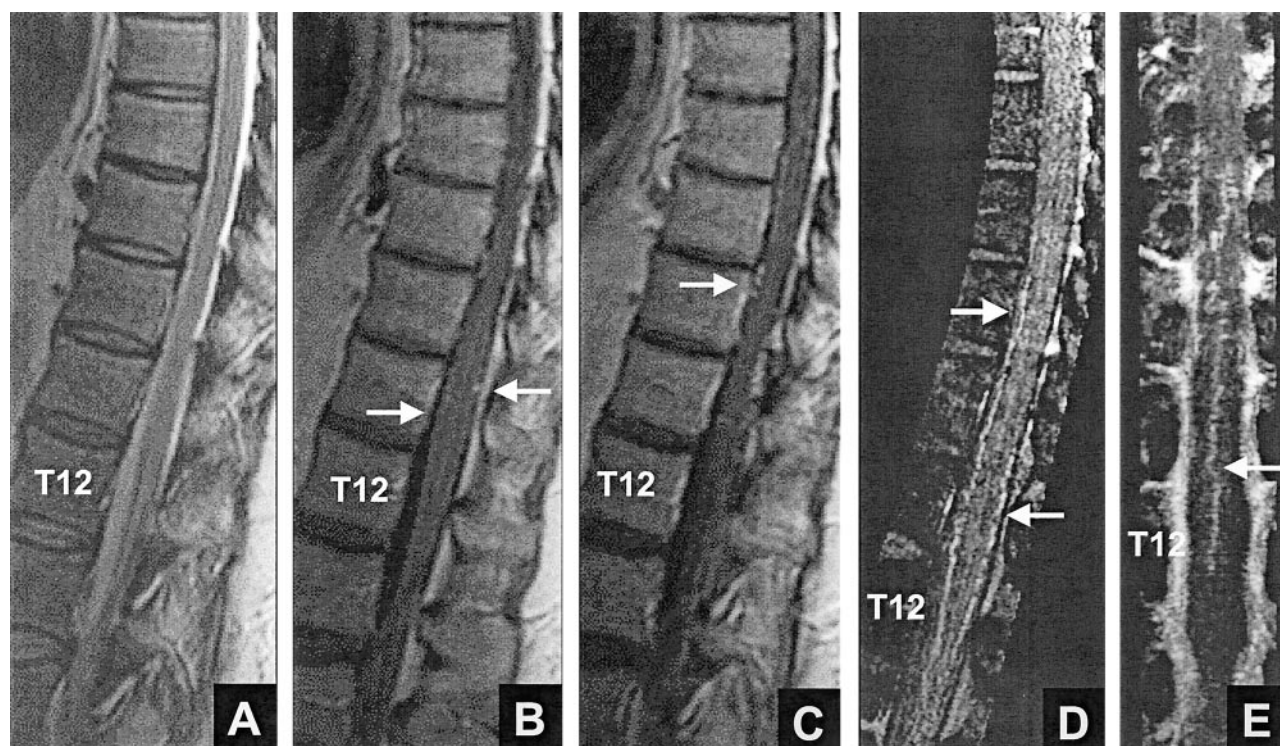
False positive result for reviewers 1 and 2: normal intradural vessels. Both reviewers thought that a fistula was present based on MR imaging (false positive, A–C) and based on MR imaging plus MR angiography (false positive, A–E).
